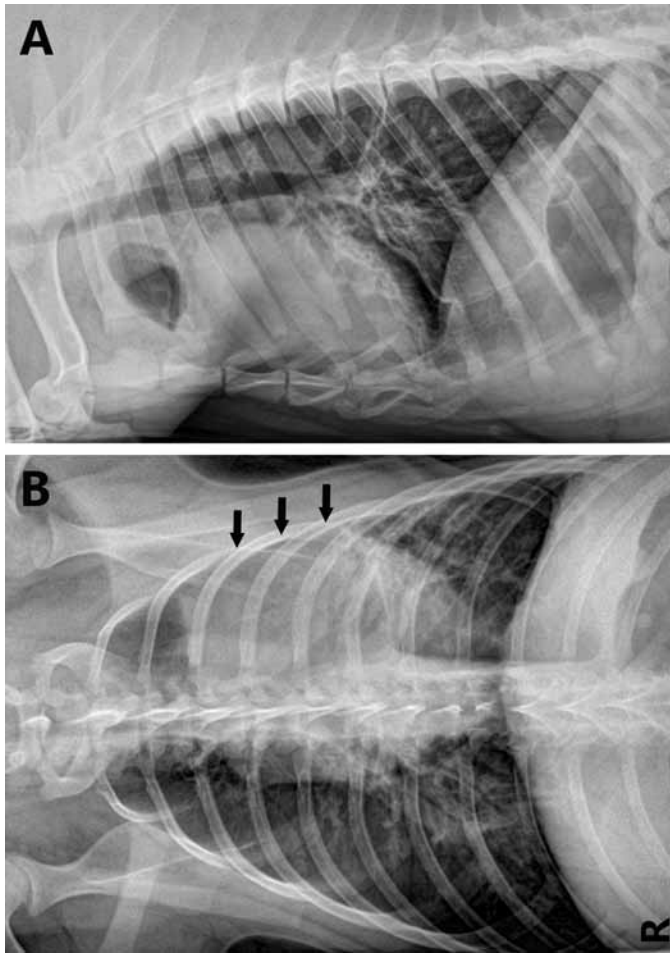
Radiographs taken after administration of antibiotics. (A) Lateral thoracic view demonstrates the return of correct tracheal position and diameter. Radiographic pattern of inflammation is present in the caudal lobes of the lung. (B) Ventrodorsal thoracic view demonstrating the noticeable regression of opacity in the overall thoracic cavity, with arrows pointing to focal opacity in the left aspect of the thoracic cavity adjacent to the thoracic wall.
